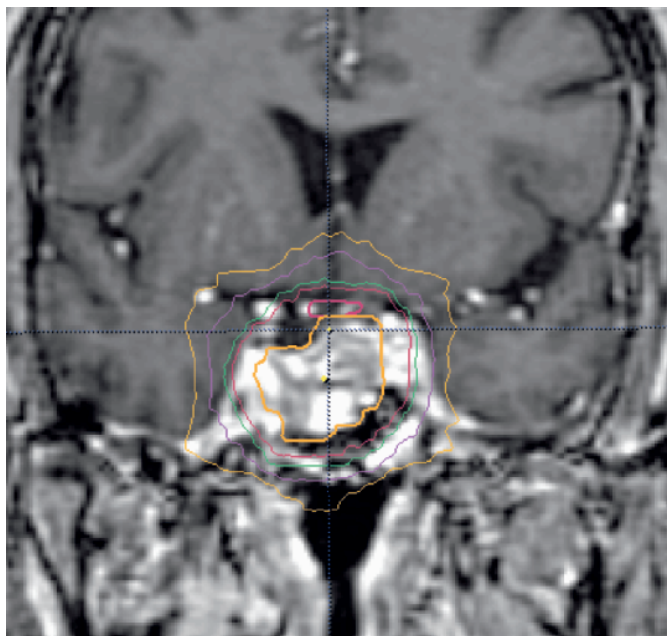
Coronal contrast-enhanced T<sub>1</sub>-weighted MR image demonstrates pituitary adenoma and superimposed LINAC stereotactic radiotherapy isodose lines. Isodose lines displayed, from the adenoma (heavy yellow) and chiasm (heavy red) are: 90% (red), 80% (green), 50% (purple), 30% (yellow), respectively.
